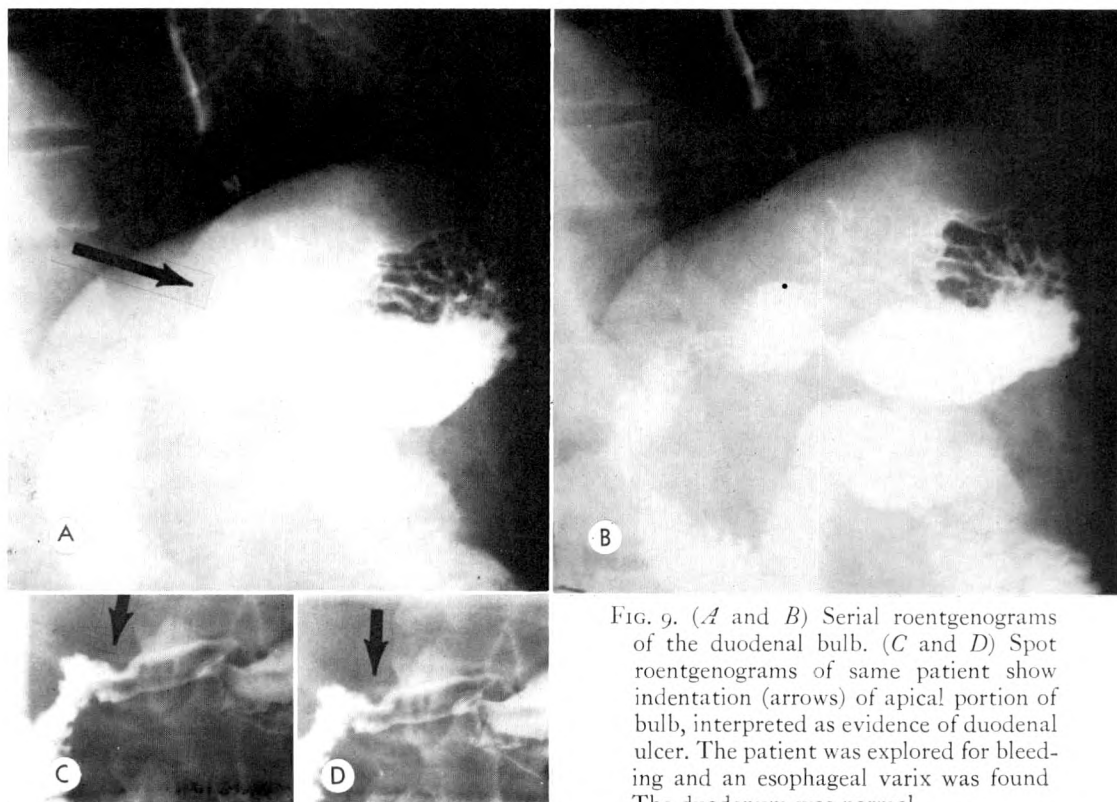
(A and B) Serial roentgenograms of the duodenal bulb. (C and D) Spot roentgenograms of same patient show indentation (arrows) of apical portion of bulb, interpreted as evidence of duodenal ulcer. The patient was explored for bleeding and an esophageal varix was found. The duodenum was normal.
